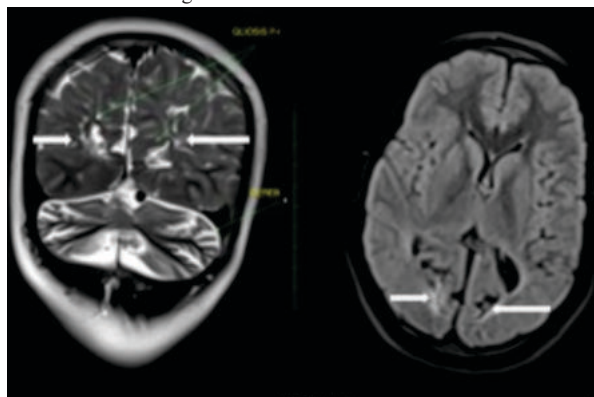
A Five-year Old Male Child With Occipital Regions Of Gliosis Seen On T2 Coronal And FLAIR Axial Images, Shown By Arrows.
